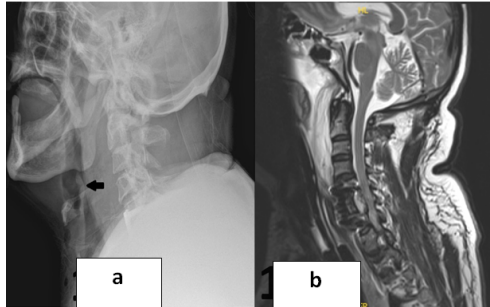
a): Lateral neck radiograph showing increased retropharyngeal shadow, airway shadow is compressed between epiglottis and posterior pharyngeal wall (Black arrow); b): MRI image sagittal view T2 weighted cervical spine showing prevertebral soft tissue thickness and hyperintensity extending from C5 vertebra to clivus.
